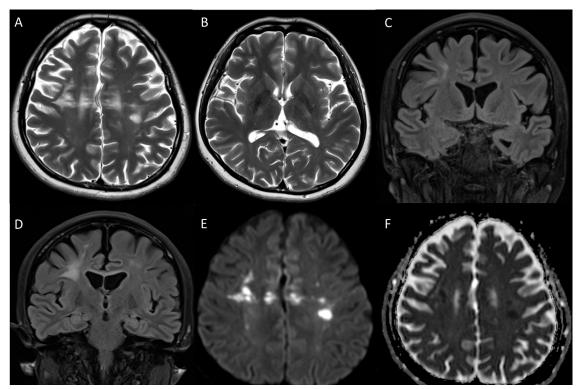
Initial brain MRI. A and B: T2-weighted axial images showed signal changes in bilateral frontoparietal deep and subcortical white matter and corticospinal tracts in the posterior limb of internal capsules associated with generalised cerebral volume loss that exhibited frontal lobe predominance. C and D: Fluid-attenuated inversion recovery coronal images corroborated findings of T2-weighted images but also showed involvement of body of the corpus callosum. E and F: Diffusion-weighted and apparent diffusion coefficient axial images showed multiple areas of restricted diffusion in bilateral centrum semiovale. MRI: Magnetic resonance imaging
